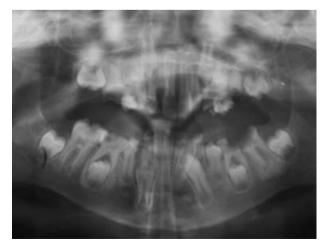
Panoramic X-ray of patient with DEB.
